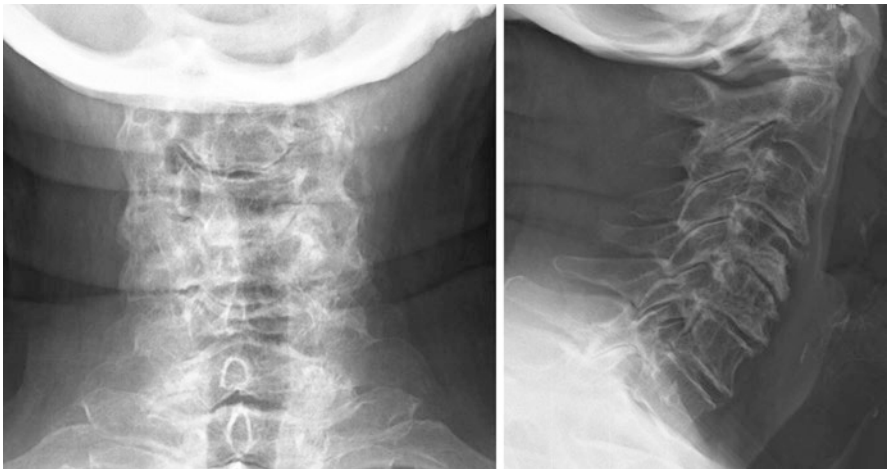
An AP and lateral radiographs of the cervical spine of an 80 years old female demonstrating spinal degenerative disc disease with reduced intervertebral disc height, subchondral sclerosis of the endplates as well as anterior and posterior osteophytes. Mild facet joints osteoarthritis is also present
